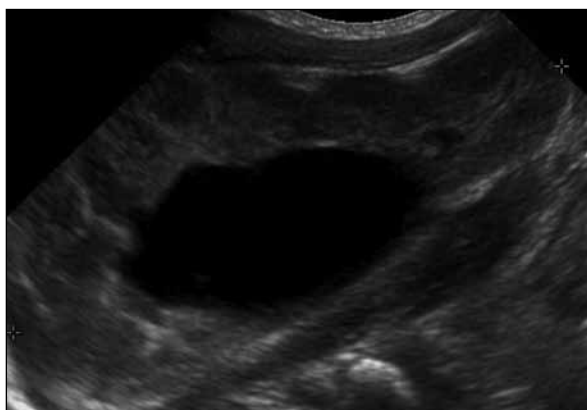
Ultrasonography of the right kidney showing a centrally located cystic structure, representing hydronephrosis with dilated renal pelvis. Renal parenchymal echogenicity and thickness are normal
